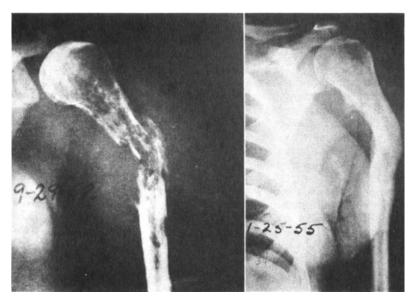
Levin case of an osteogenic sarcoma in a female aged 29. (*Left*) Roentgenogram reveals massive destruction with pathologic fracture; a biopsy confirmed the diagnosis, but malignant giant-cell tumor could not be excluded. (*Right*) Roentgenogram 3 years later shows complete healing. (From E. J. Levin. 1957. By permission of *Cancer* 10: 377.)
